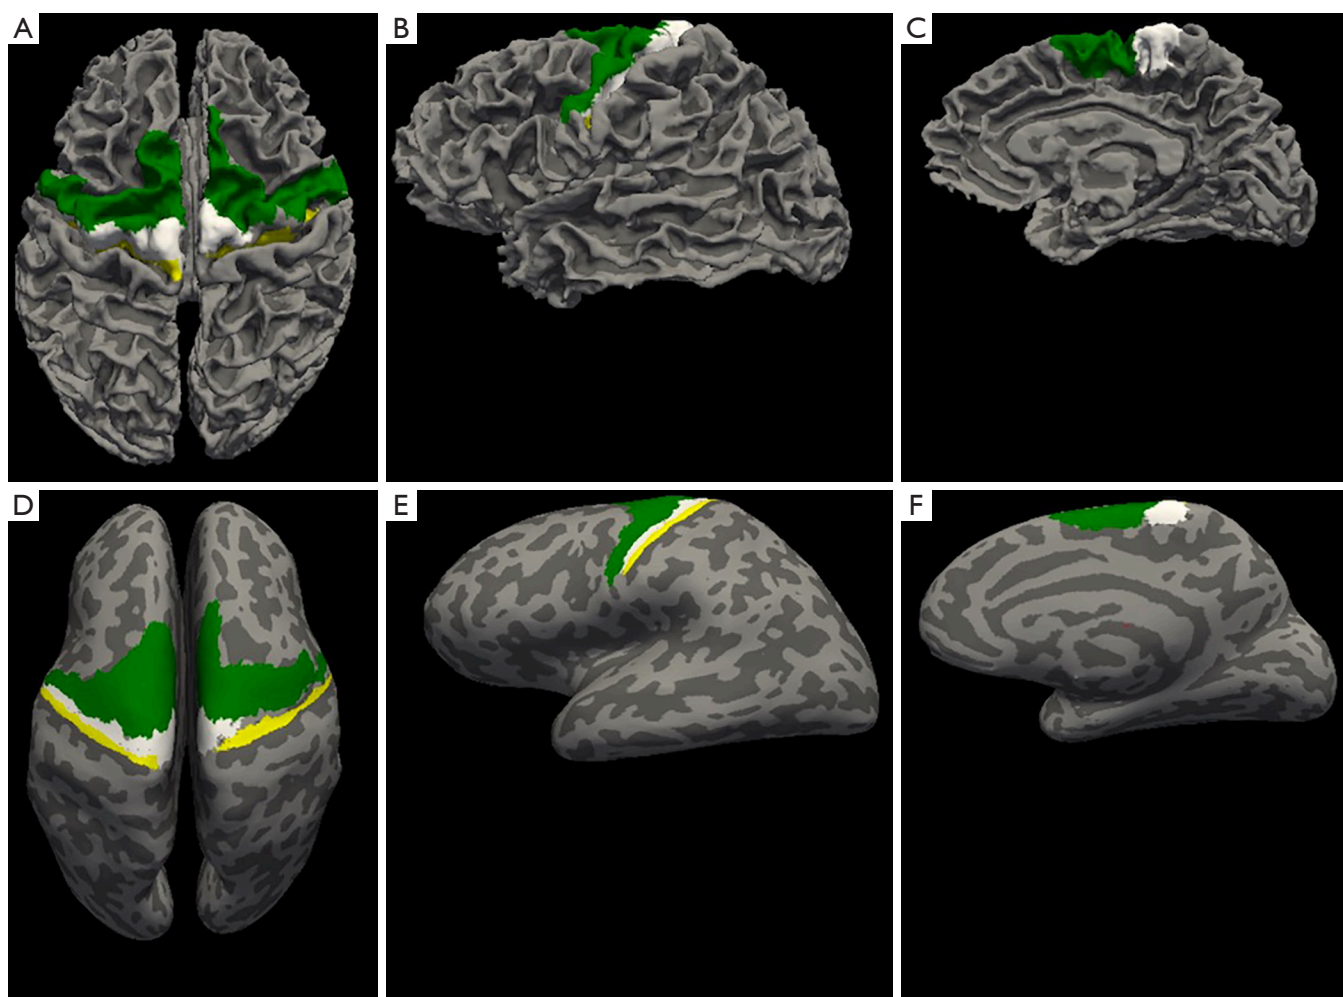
T1-weighted image based automated parcellation of the primary motor area (BA 4) and pre-motor area (Brodmann area 6) using FreeSurfer. The labels are anterior BA 4 (white), posterior BA 4 (yellow), pre-motor area (green). (A,B,C) shows top view, lateral view, and midsagittal view respectively of normal surface. (D,E,F) show top view, lateral view, and midsagittal view respectively of the inflated surface.
